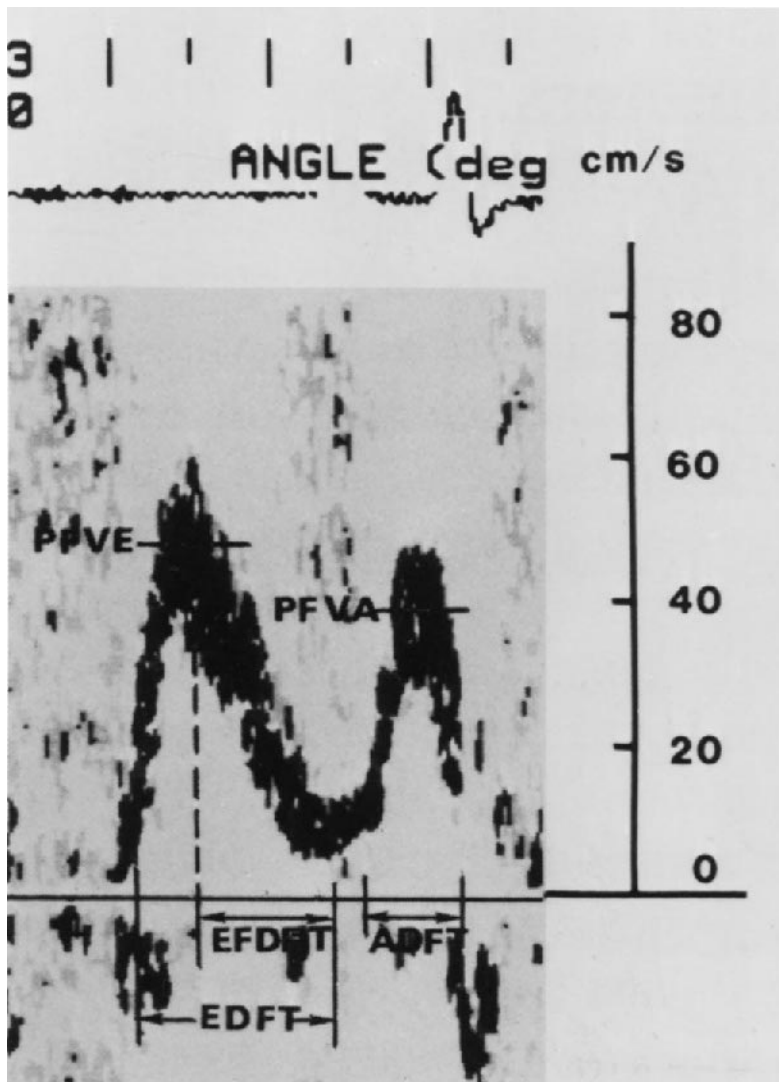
Normal flow velocity recording at the level of the mitral valve from the apical four-chamber view depicting the method for making Doppler measurements. Mitral peak flow velocity in early diastole (PFVE) and in late diastole (PFVA) were measured (cm/s) at the midpoint of the darkest portion of the spectrum at the time of the maximal flow velocity in early and late diastole, respectively. Early diastolic flow time (EDFT), late diastolic flow time (ADFT), and early diastolic deceleration time (EFDFT) were measured as noted. (Reprinted from Ref. 25, with permission.)
